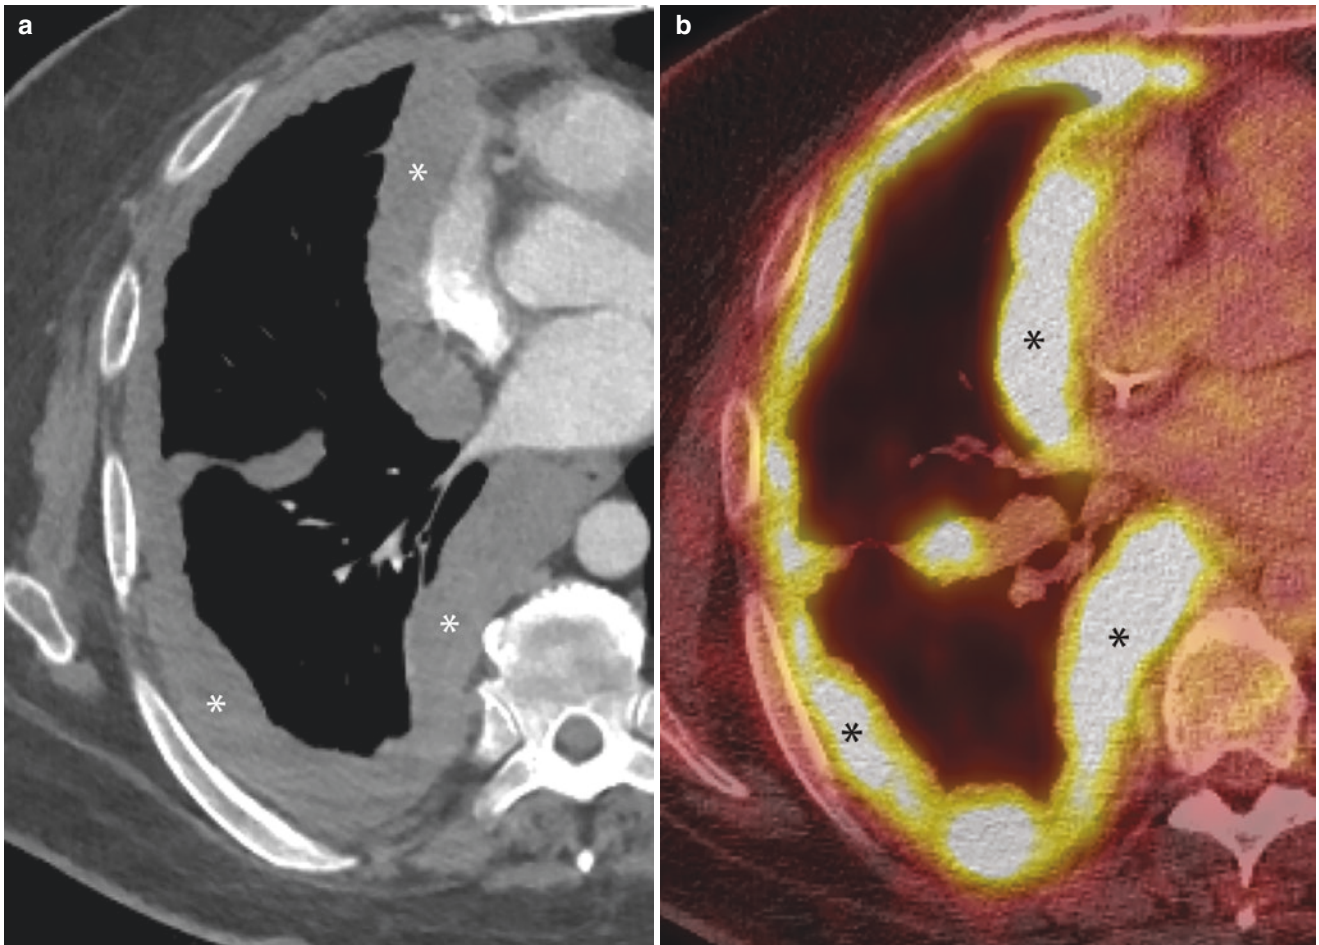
(a) Contrast-enhanced axial CT demonstrates circumferential “rind-like” pleural thickening and nodularity (*) in the right hemithorax, (b) axial FDG PET/CT shows increased FDG uptake (*) in the right circumferential nodular pleural thickening consistent with malignant pleural mesothelioma
